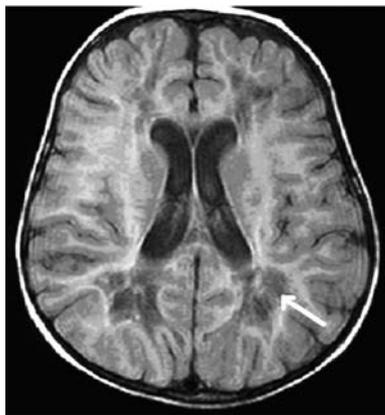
Axial FLAIR showed white matter degeneration and rarefaction.
